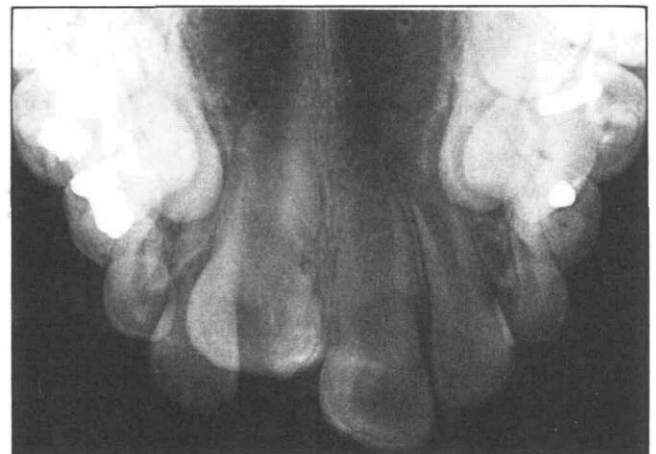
Occlusal radiograph of unerupted incisor.
